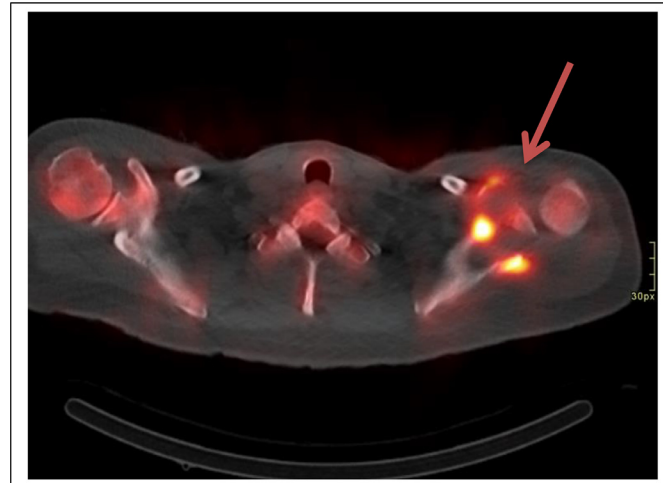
Hypermetabolic activity of the bone and soft tissue on the shoulder lesion with PET-CT.
